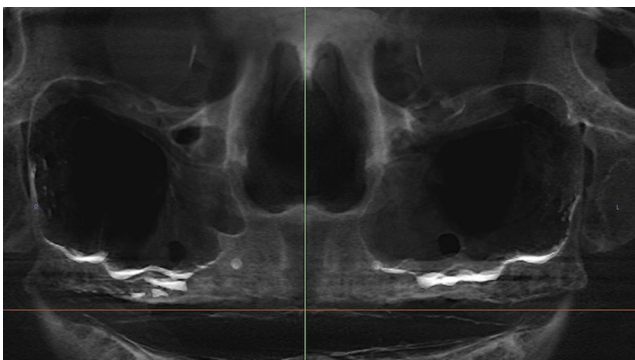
Post-operative CBCT assessment with a radiopaque contrast
